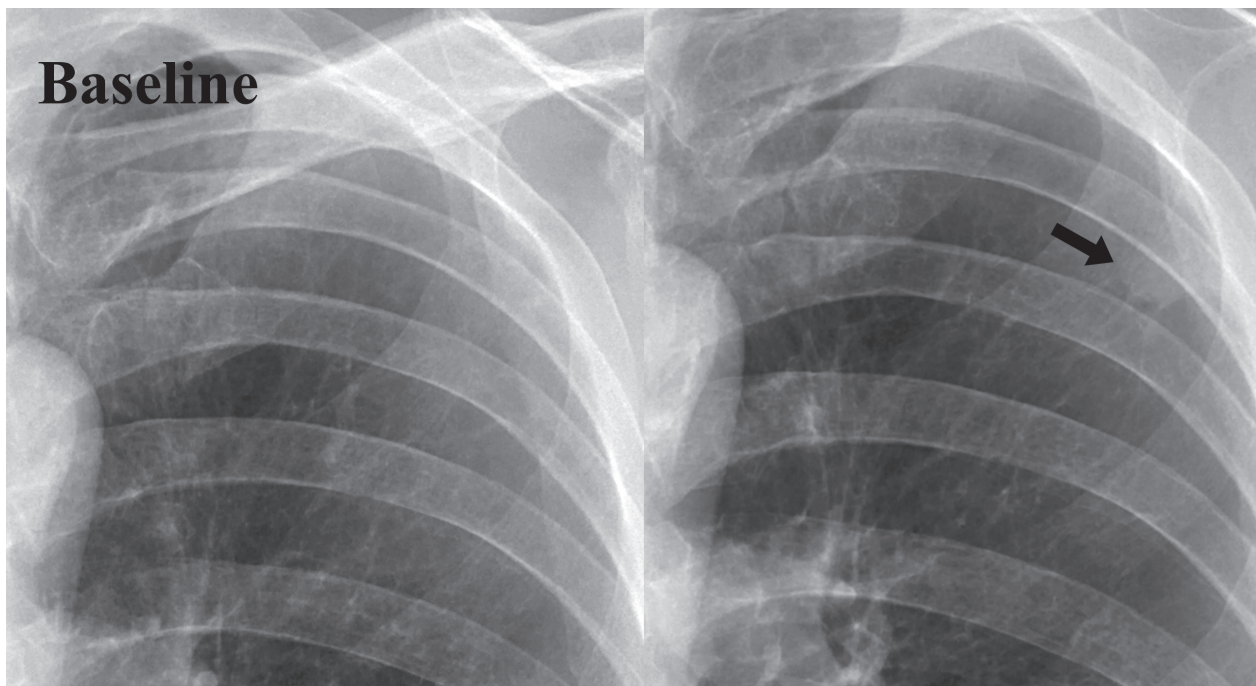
Chest X-ray revealed a small nodular opacity in the left upper lung zone.
